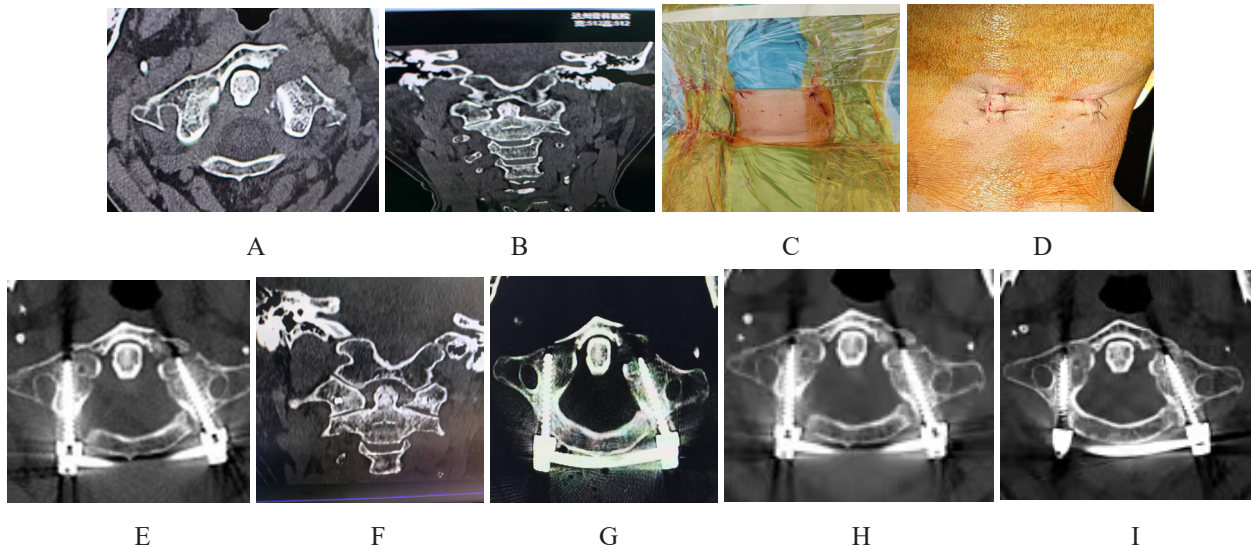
A–B. Preoperative images; C. Intraoperative needle placement; D. Postoperative incision; E–F. Postoperative CT images; G. 1 month postoperatively (callus formation); H. 2 months postoperatively; I. 3 months postoperatively (bone healing).
